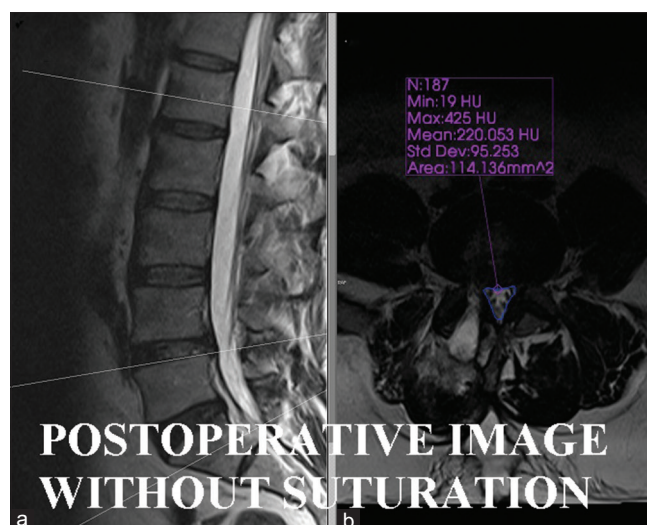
(a) Sagittal, (b) Axial. Show postoperative MRI of patient without suturation of PLL: The intradural area was moderately increased to 114.136 mm². PLL: Posterior longitudinal ligament
